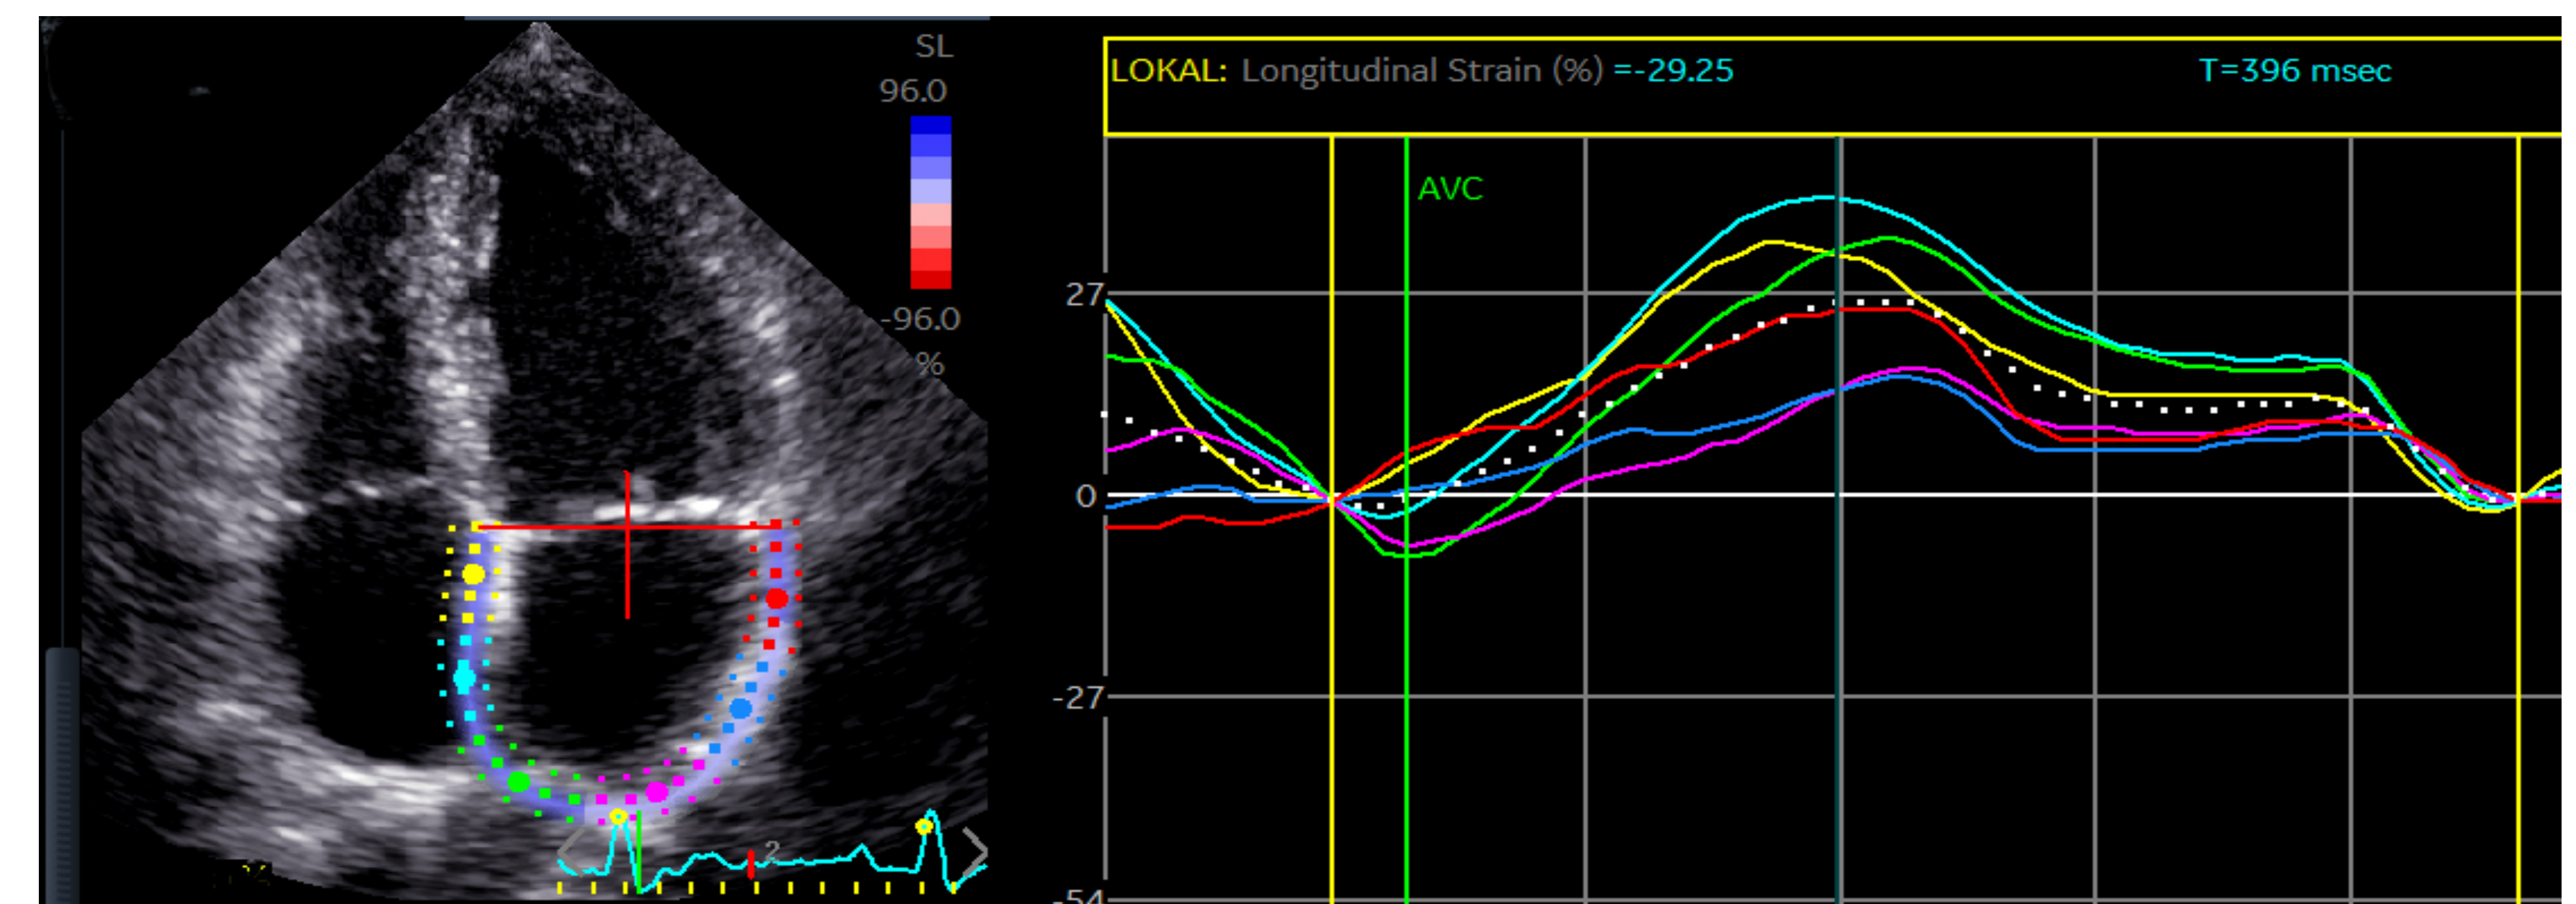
Two-dimensional peak atrial longitudinal strain from apical 4-chamber view.
